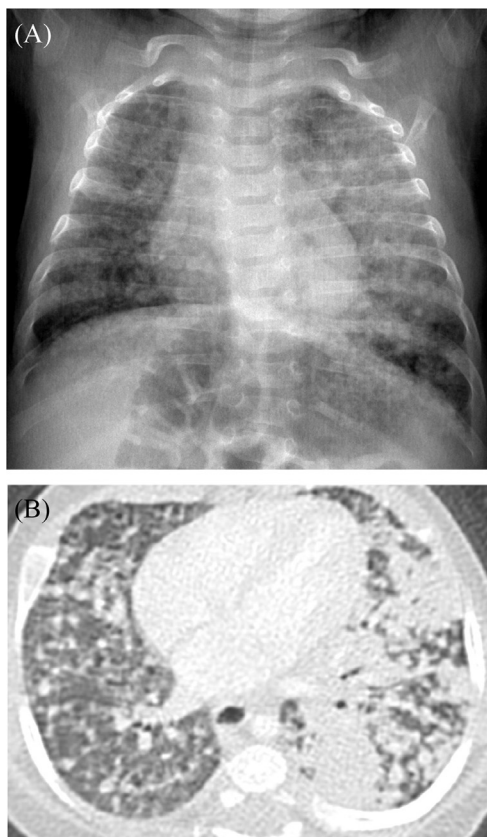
(A) Chest radiograph shows extensive reticulonodular infiltrates in both lungs. Nodules are coalescing to form areas of consolidation in the left lung and (B) contrast-enhanced axial computed tomography image at lung window setting revealed multiple pulmonary nodules in both lung and areas of consolidation in the left lung.
